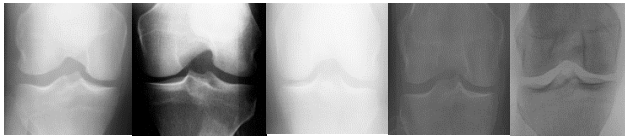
Knee X-ray images corresponding to Grade 0 (Normal). Samples belonging to good contrast, poor contrast, highly illuminated, poorly illuminated, and negative-like images.
